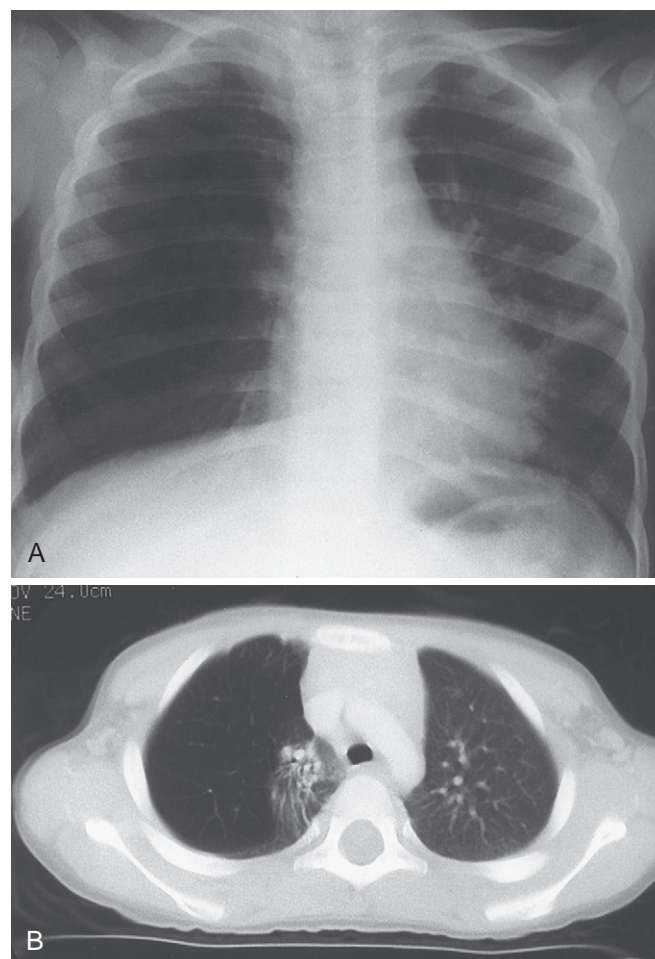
A, Chest radiograph in a 3-year-old child with acquired lobar emphysema who developed pneumonia with respiratory syncytial virus. B, Computed tomographic scan of chest reveals collapsed upper lobe and emphysematous middle lobe.
